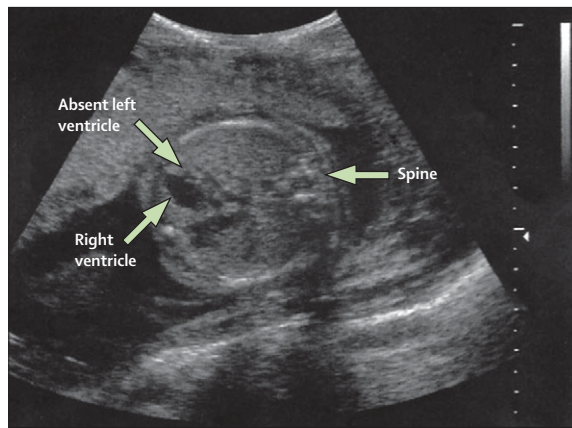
Fetal echocardiogram showing a small hypoplastic left ventricle
